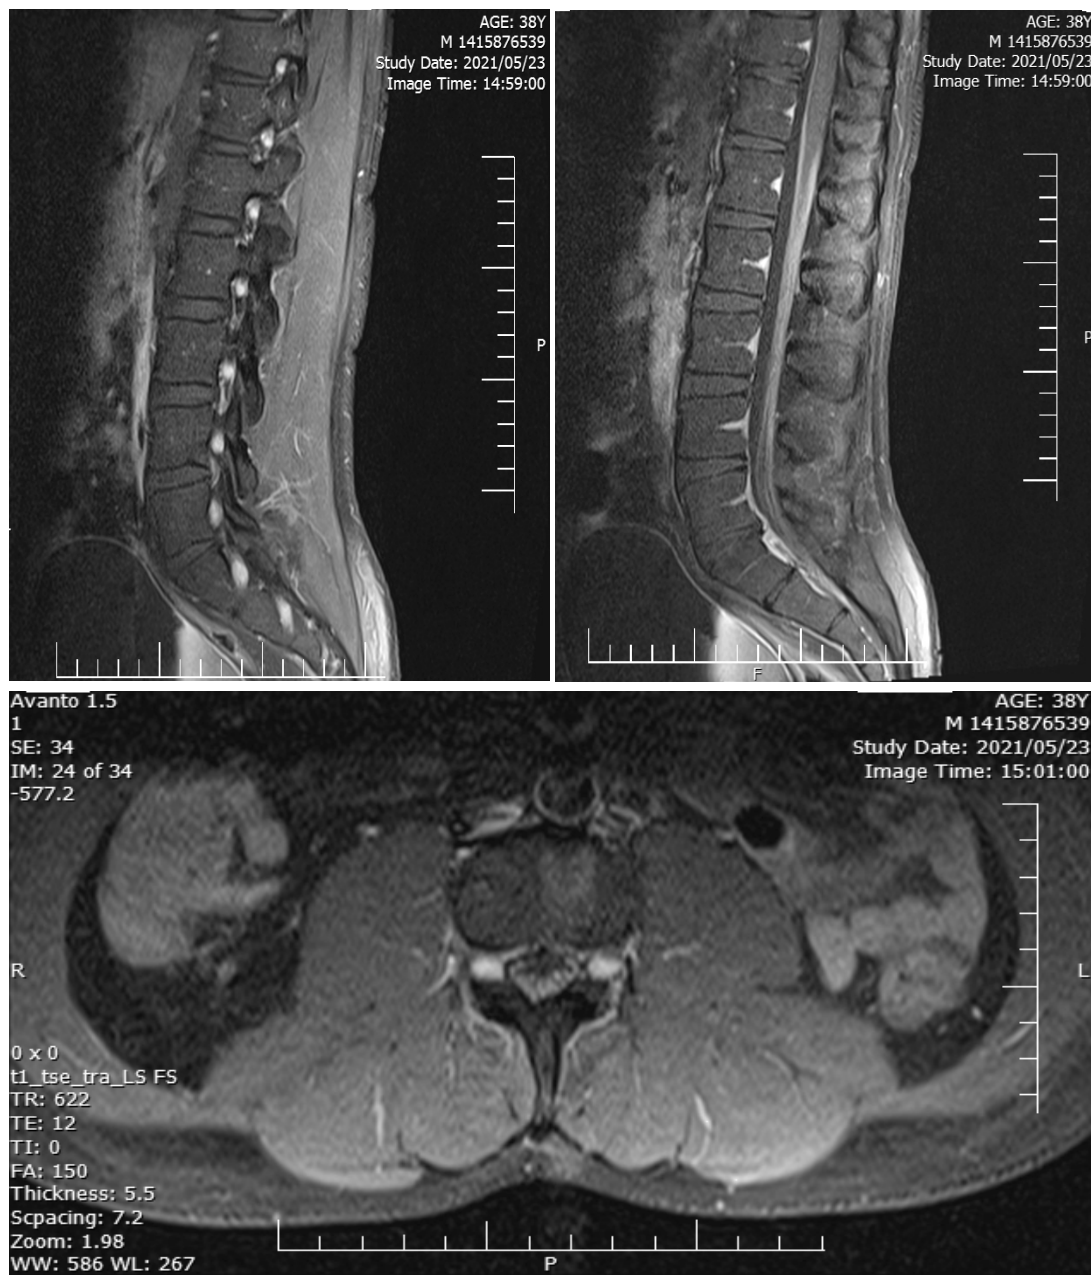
Lumbosacral magnetic Resonance Imaging (MRI) with contrast
